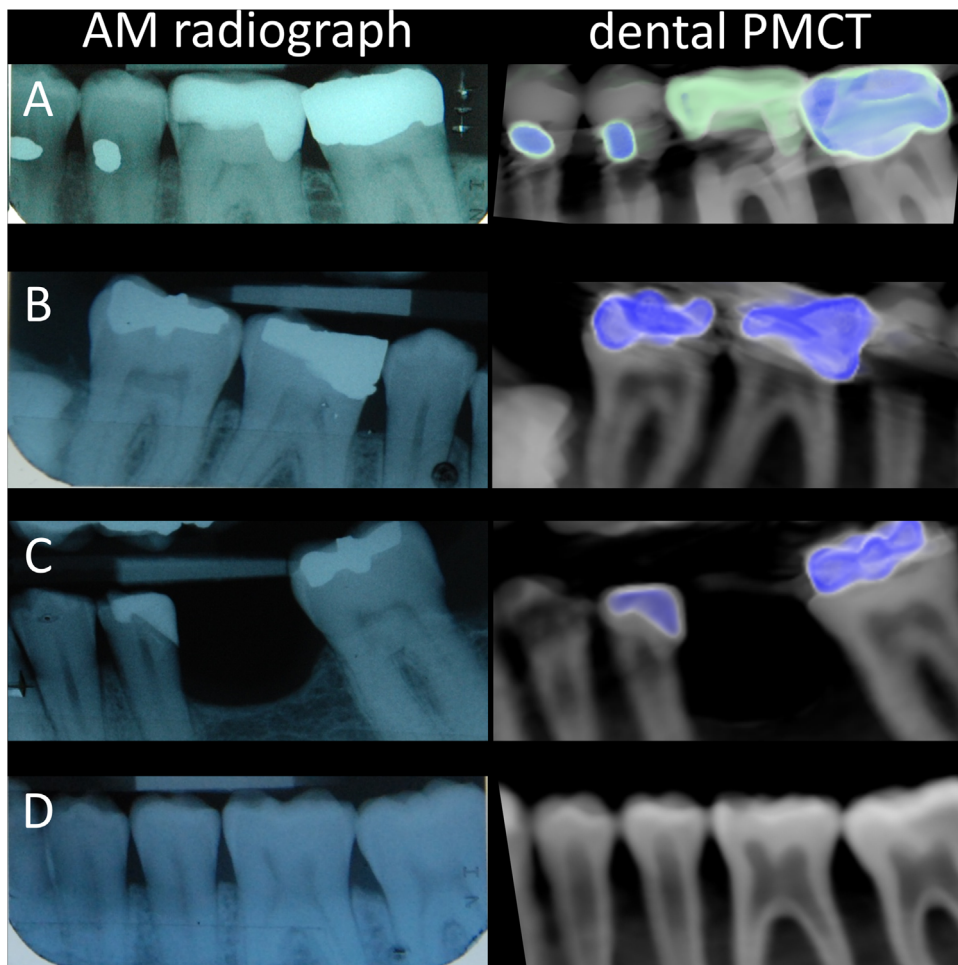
Four sample images of corresponding ante mortem radiographs and reconstructed post mortem computed tomography (PMCT) of one quadrant. A–C feature cases where restorative materials are present. D features a case without restorative materials. PMCT has several advantages over plain film dental images, including three-dimensional image reformatting, acquisition in a non-invasive fashion, and anatomical and pathological information not only of the teeth but of the surrounding connective tissue including the mandibular and the paranasal and maxillary sinuses. The main limitation of dental PMCT is the occurrence of metal artifacts (beam hardening artifacts) from restorative materials with a high radiologic opacity which obscure the edge detail of restorative materials. (e.g. A and B). This study found no evidence that the accuracy of this approach suffers from the presence of CT image artifacts.
